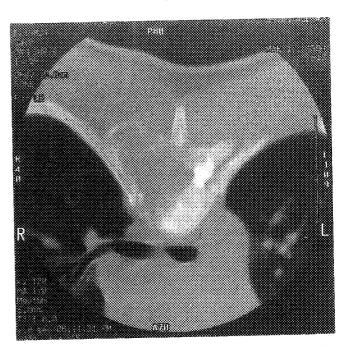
Unenhanced axial computed tomographic image windowed for bone demonstrates the preservation of a cortical rim of bone surrounding the destructive process of the right body, pedicle, transverse process, and lamina of the fifth thoracic segment.
